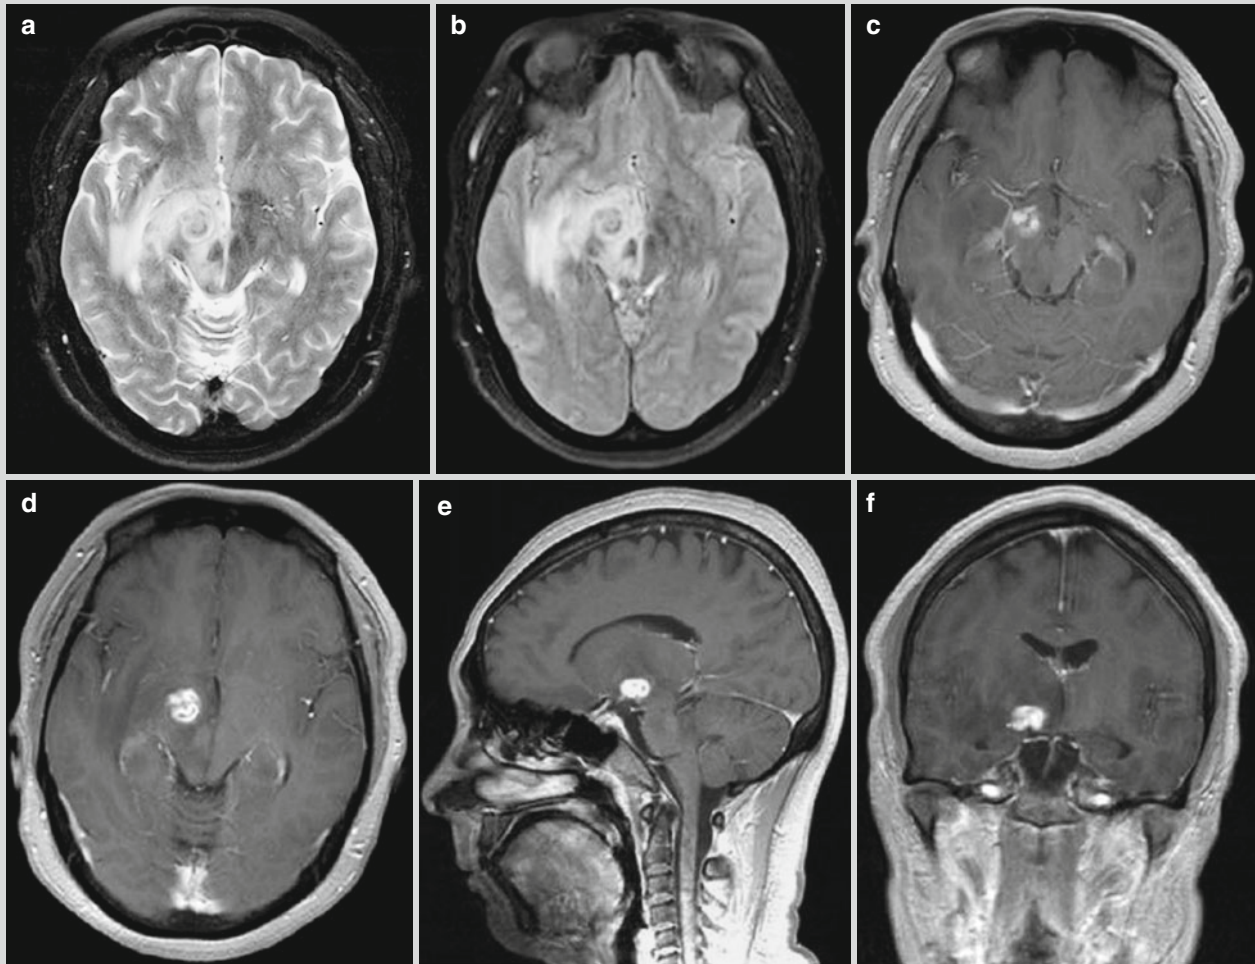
Gumma neurosyphilis. (a, b) Transverse MR imaging demonstrates round-like long T2 signal at the right mesencephalon and cerebral peduncle, with internal uneven and mixed signals. The center of the lesion is demonstrated with slightly low signal. And the lesion is demonstrated with surrounding large flakes of high-signal
